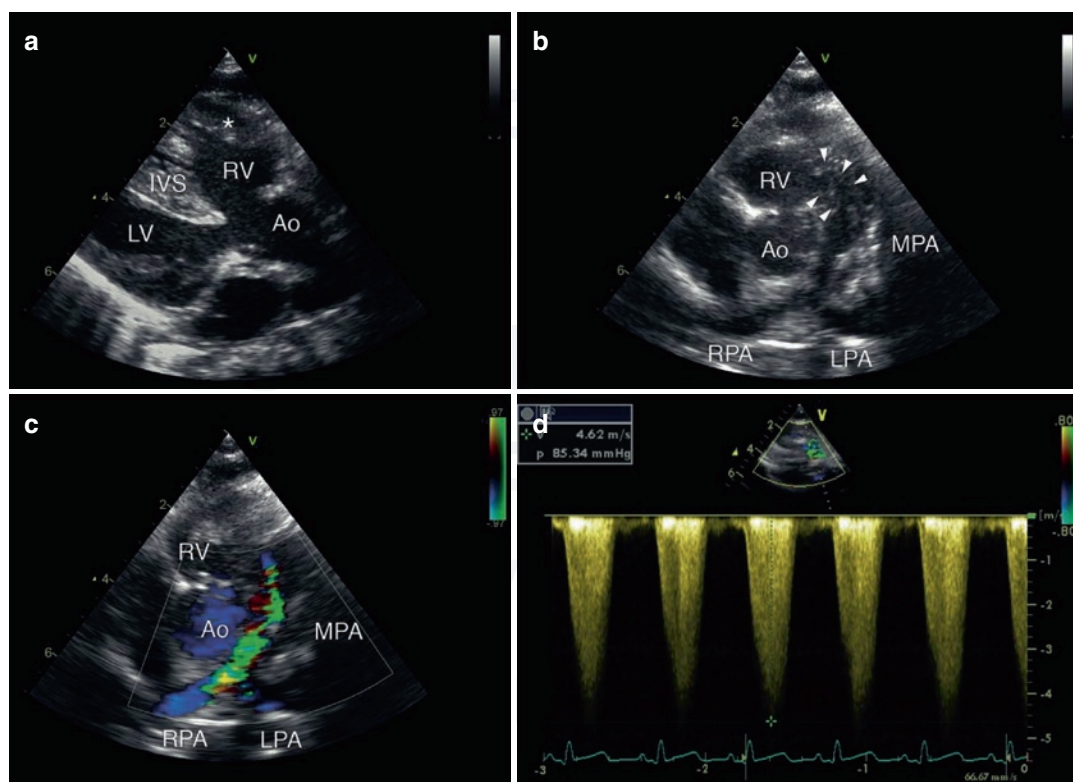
Two-month-old female patient with uncorrected tetralogy of Fallot. Using echocardiography with 2D grey-scale imaging the tetrad of abnormalities can be evaluated (a, b): overriding of the aorta (Ao) over the interventricular septum (IVS), with subsequent ventricular septal defect, hypertrophy of the right ventricle (RV, *asterisk*) and narrowing of the right ventricular outflow tract (*arrowheads*). Using 2D color Doppler echocardiography (c) turbulence starting in the right ventricular outflow tract
